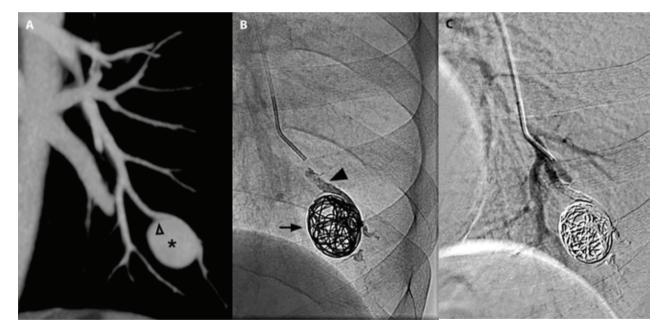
a) CE-CT maximum intensity projection (MIP) on the paracoronal plane demonstrates the saccular dilation of the pulmonary artery tributary of the posterior segment of the left pulmonary lobe (asterisk). A septum of the vascular wall can be observed, which divides the lumen of the afferent vessel from the lesion sac (empty arrowhead). b) Post procedural fluoroscopy control demonstrates distribution of the radiopaque embolizing liquid inside the tributary vessel (black arrowhead) and the complete occupation of the vascular pseudoaneurysmatic sac by detachable coils (arrow). c) Post procedural digital subtraction angiography (DSA) shows the embolization of the pulmonary artery tributary of the posterior segment of the left pulmonary lobe with no contrast medium inside the PSA.
